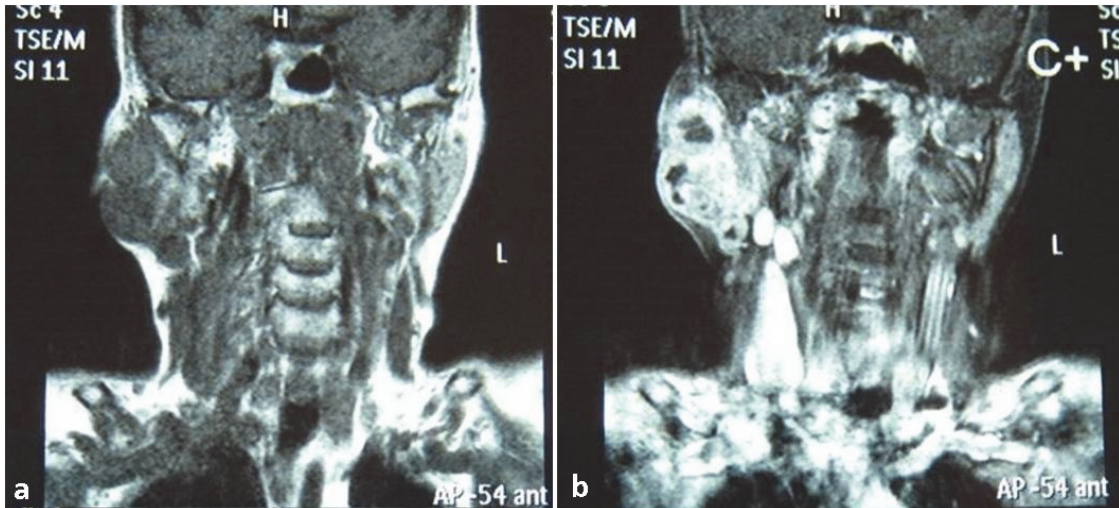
Head and neck magnetic resonance imaging (MRI) showing the intraglandular hypo-intense mass in the right parotid gland on T1 images; T2 images show a 45x50mm mass with heterogeneous signals, partially cystic areas, and extensions towards the stylomastoid foramen.
